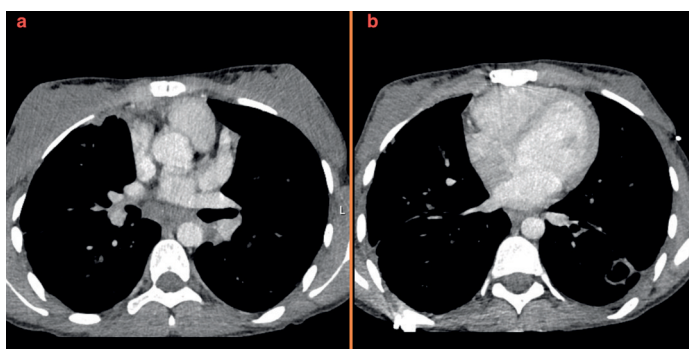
Contrast enhanced thorax CT
